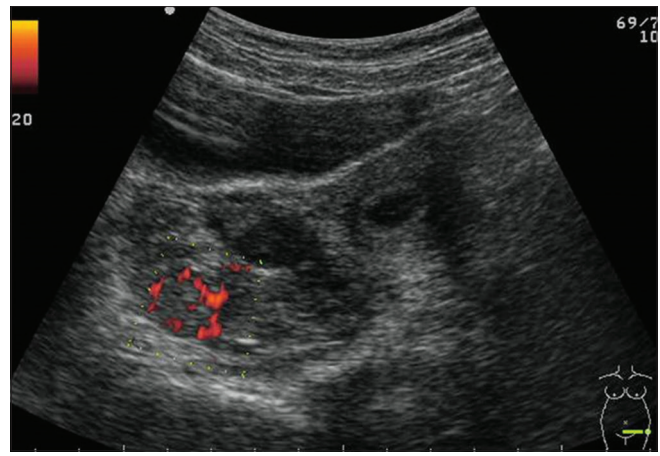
Color Doppler (Aloka SSD 4000, convex probe 5–2 MHz) evaluation of an empty sac of mean gestational age 5w2d outside the uterus in right adnexa with normal uterus and right ovary showing “ring of fire” appearance
